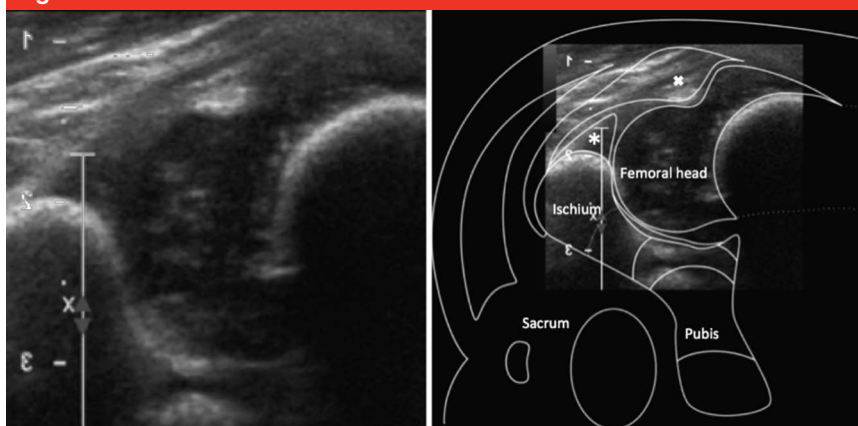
Figure demonstrating transverse ultrasonography of the hip with anatomical landmarks. The bony landmarks are labeled as follows: femoral head, ischium, pubis, and sacrum. The posterior labrum is represented by * and the gluteus medius by x.
